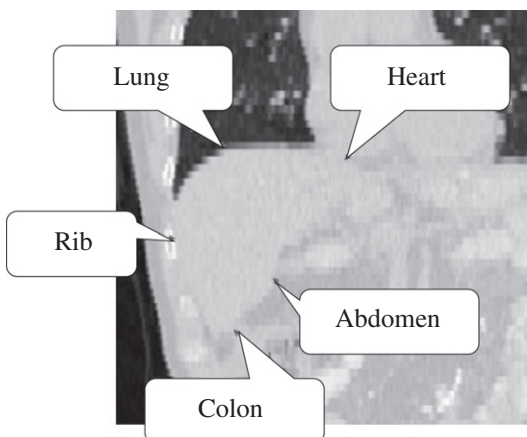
An example of liver boundaries from CT images. It includes boundaries between liver and rib, lung, heart, abdomen and colon that show heterogeneous appearance in local shapes.
